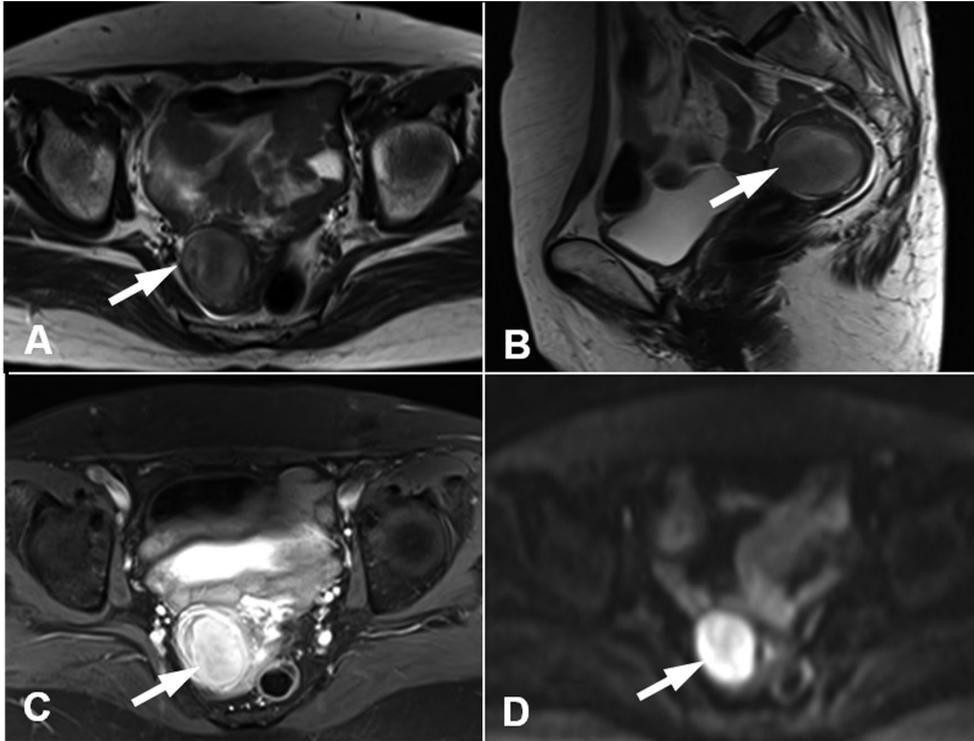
Mixed endometrial stromal and smooth muscle tumor of the uterus. (A, B) Axial (A) and sagittal (B) T2-weighted images showing a well-defined endometrial mass (arrow) with heterogeneous signal intensity. (C) Contrast-enhanced fat-suppressed T1-weighted image showing the mass with marked enhancement (arrow). (D) Diffusion-weighted image at  $b = 1,000 \text{ s/mm}^2$  demonstrating restricted diffusion in the mass (arrow).
